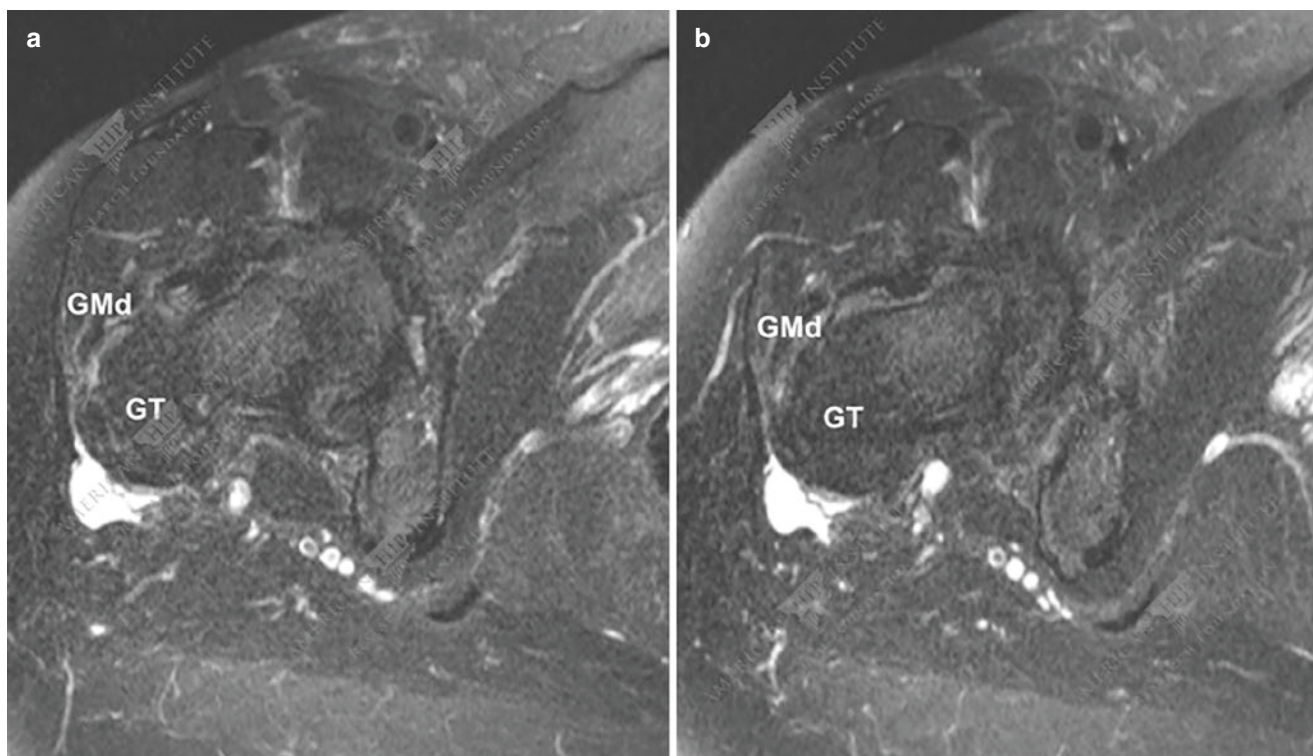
(a, b) Axial T2 fat-saturated weighted MRI. Increased signal intensity lateral to the greater trochanter can be attributed to tearing/tendinosis of the gluteus medius (GMd) tendon at its insertion as well as trochanteric bursitis
